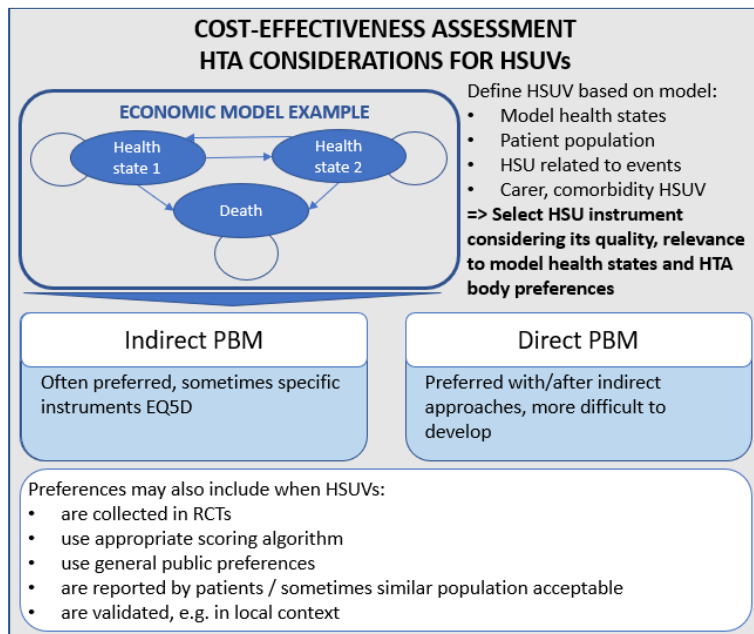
represents the different considerations when selecting HSUVs to include in an economic model for the purpose of HTA. The HSUVs to include should correspond to the model health states for the treatment and control arms, and be representative of the patient population. Other HSUVs relating to adverse events, co-morbidities or carers are to be included if there is correspondence to the model health states and if they are relevant in determination of a change with and without treatment. HTA bodies have different preferences or requirements in the types of PROMs to include, which are listed in the figure.
